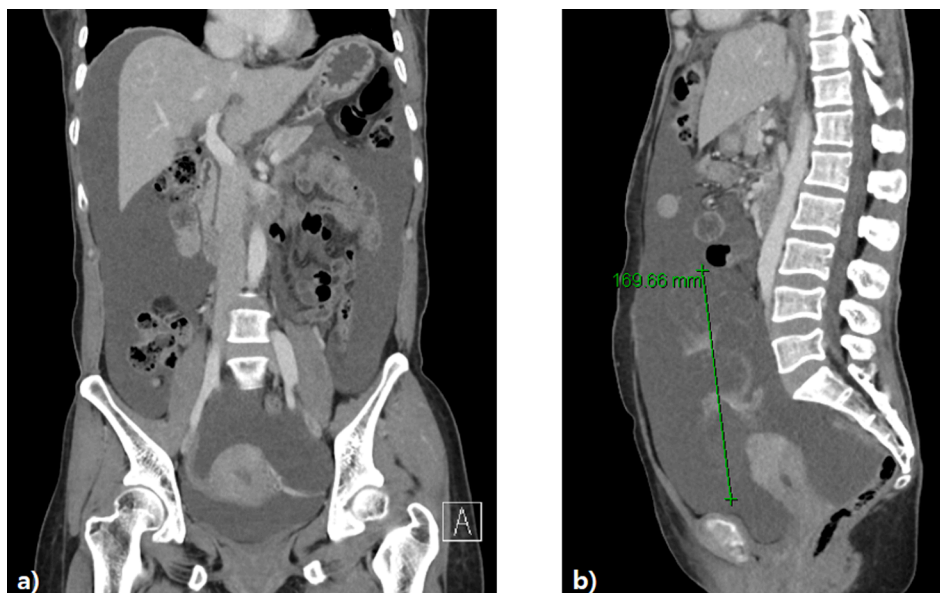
Initial CT scan revealed large amount of ascites (a), and about an approximately 17 cm cm-sized multi-septated cystic left ovarian mass (b).
